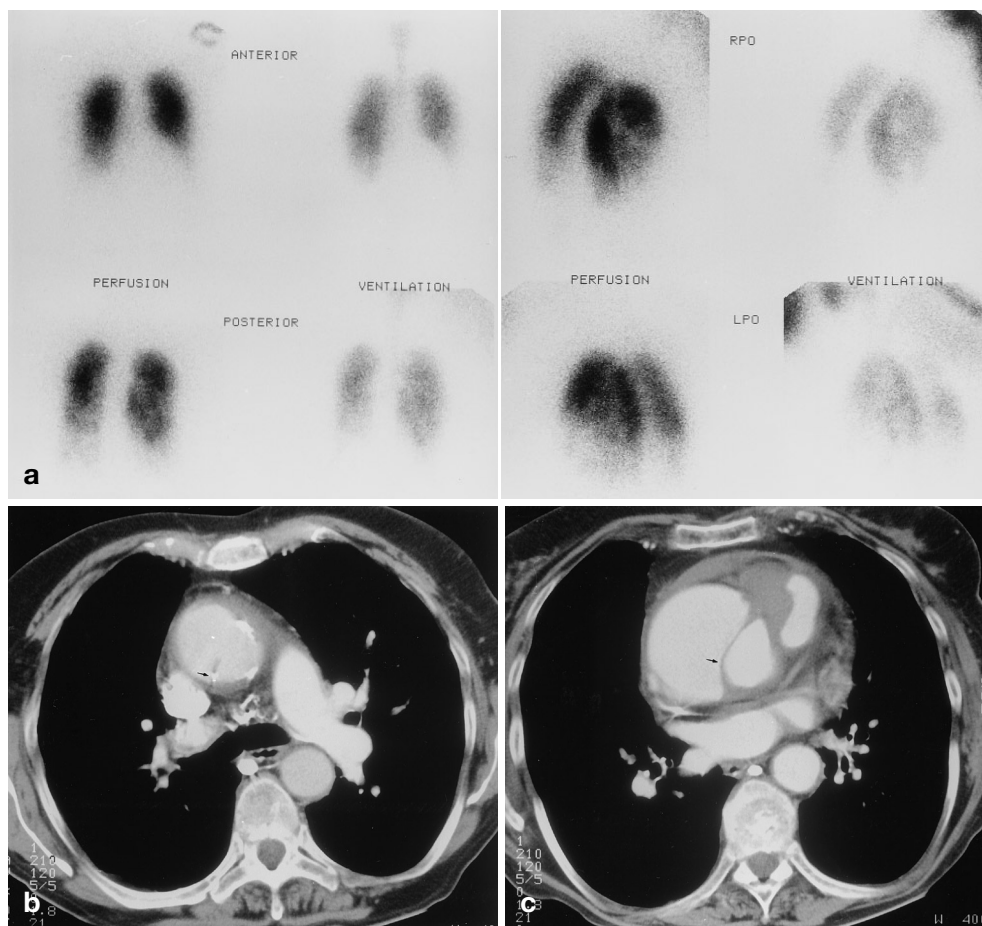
A 69-year-old with acute sharp anterior chest pain and shortness of breath. a The V/Q scan shows diffuse nonsegmental matching defects. Panel scored the V/Q strategy as inconclusive. b, c The CT scan showed no PE, but found another diagnosis: dissection of the ascending aorta (*arrow* points at intima tear)
